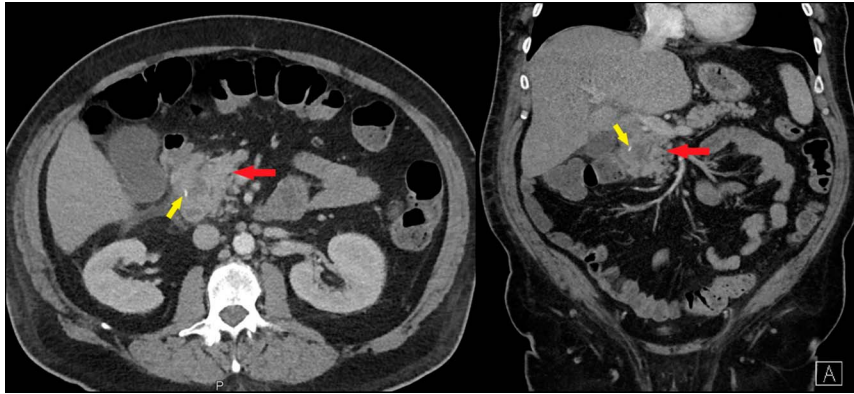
Axial and coronal views of abdominal and pelvic computed tomography without contrast showing an intramural duodenal fluid collection measuring 3.5×3.2 cm (red arrow). A linear radiolucent foreign body penetrating the duodenal wall (yellow arrow).
